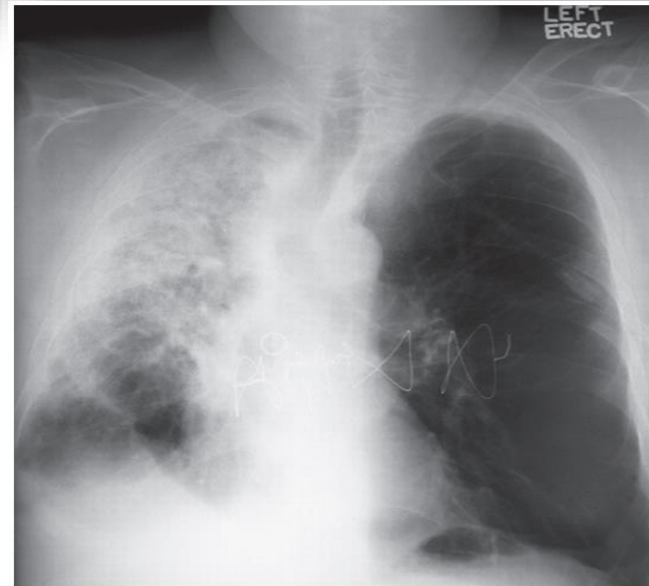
Radiograph showing classical *Staphylococcus aureus* pneumonia (courtesy of Professor Stephen Eustace, Dublin, Ireland).
